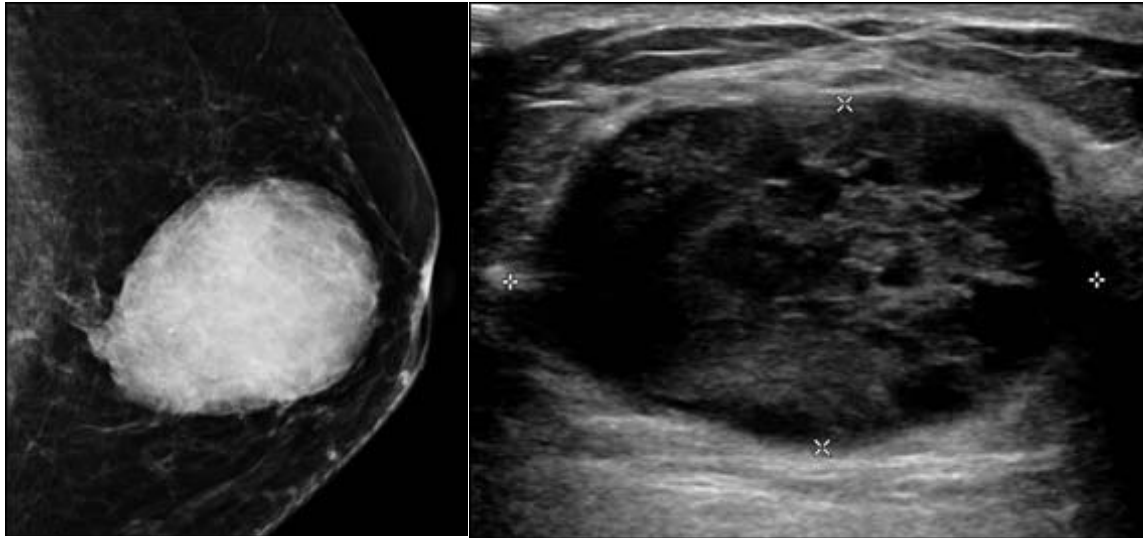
A 66-year-old female presented with palpable mass. (Right) Mammography revealed a circumscribed hyperdense mass at central part of left breast. (Left) For sonography, this mass showed a circumscribed heterogeneous-echoic appearance. Mastectomy confirmed invasive papillary carcinoma.
